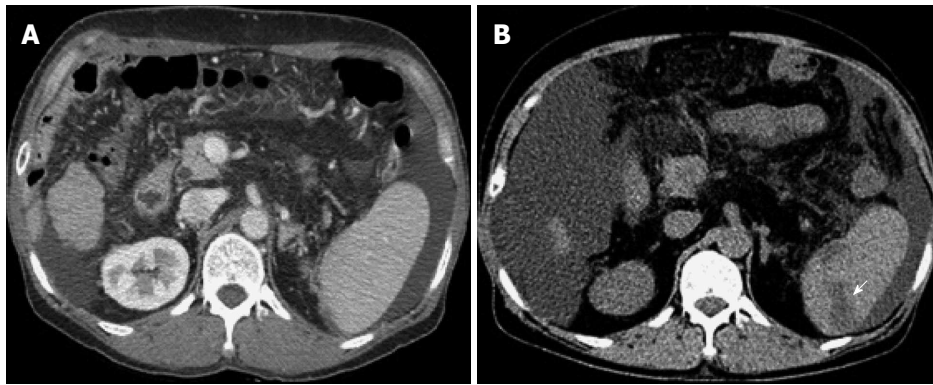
Abdominal computed tomography reveals several wedge-shaped, low attenuation lesions in the spleen, indicating infarction (arrow). A: Computed tomography (CT) before endoscopic treatment; B: CT after endoscopic treatment.
